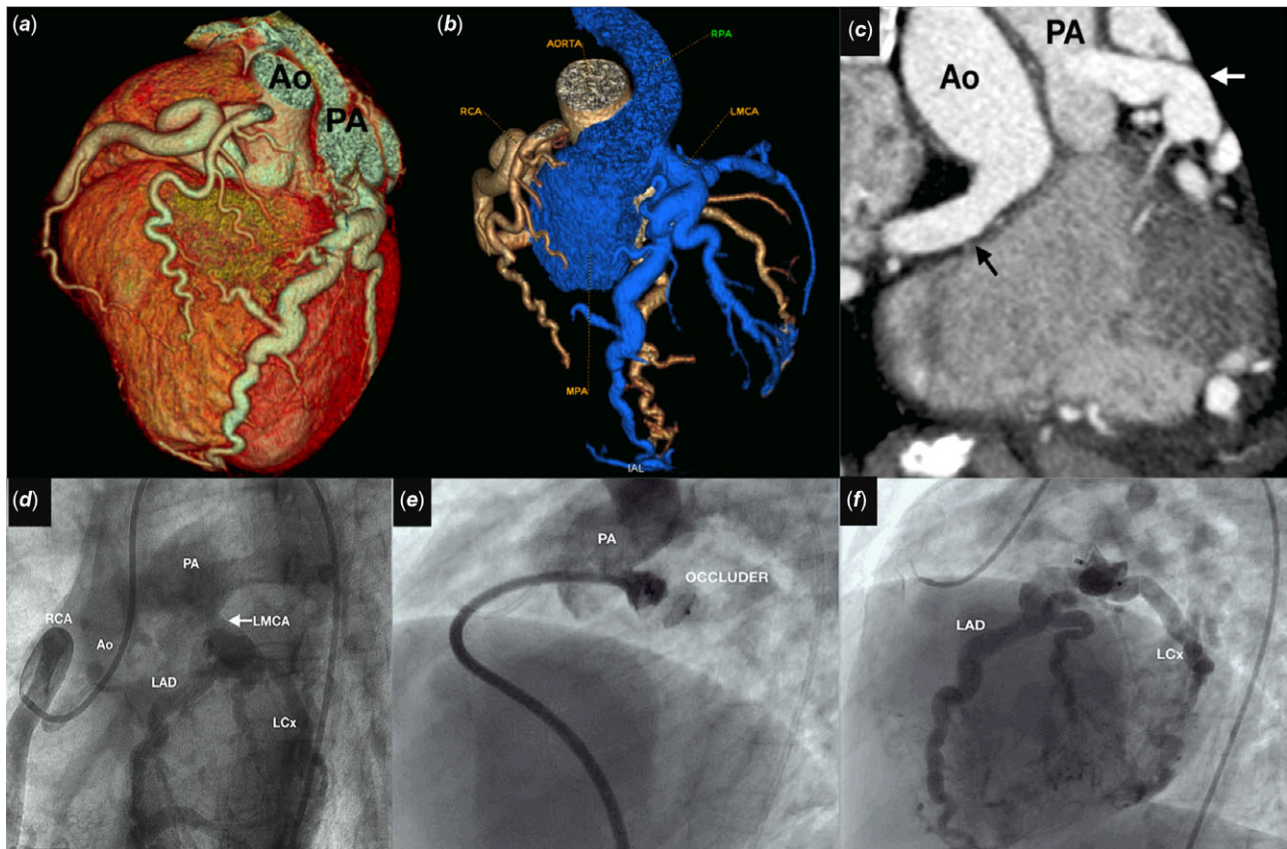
The large dilated epicardial coronaries in volume-rendered computed tomographic image (a) were color coded (b) to separate the left (blue) and right (yellow) coronary arteries. The left main coronary artery (LMCA) measured 11mm in the multiplanar reformatted image (c). A still frame (d) in LAO 40° projection from a right coronary (RCA) rotational angiogram profiled the LMCA between the pulmonary artery (PA) and left anterior descending (LAD) and circumflex (LCx) branches. Mother and child strategy assisted cannulation and occlusion of LMCA with a long sheath (e). The final right coronary angiogram (f) showed adequate filling of the left coronary system without any steal. Ao=aorta.
